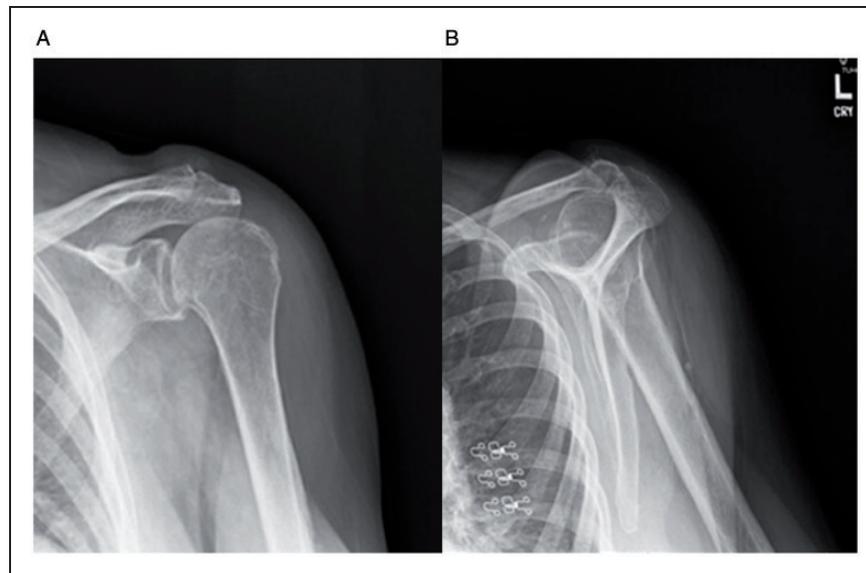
A, An anteroposterior radiograph in external rotation. B, A trans-scapular Y-view of the left shoulder demonstrating arthropathy of the acromioclavicular and glenohumeral joints with bony hypertrophy at the greater tuberosity.
